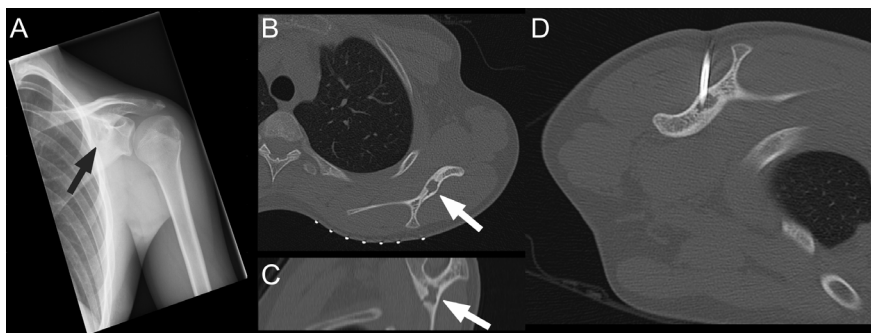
A 17-year-old boy presented with pain and some weakness around the left shoulder. Plain radiograph showed a lytic lesion in the left scapula (A, arrow). Of note, 7 years before, brain MRI (which was ordered because of central diabetes insipidus and growth hormone deficiency) showed an enhancing lesion in the infundibulum, which may have been due to extraosseous Langerhans cell histiocytosis (although not confirmed). Skeletal surveys did not reveal any bone lesions at that time. CT-guided bone biopsy of the lesion in the left scapula was performed. Axial and oblique coronal 2.0-mm pre-biopsy planning CT showed a lytic 11-mm lesion in the left scapula (C, arrow), with a sharp transition zone and focal cortical breakthrough, but no sclerotic rim, periosteal reaction, or associated extraosseous soft tissue mass. The acquired 4-mm tissue sample yielded insufficient material for a specific diagnosis to be made or to suggest a malignancy. However, the lesion proved to be Langerhans cell histiocytosis after subsequent resection.
